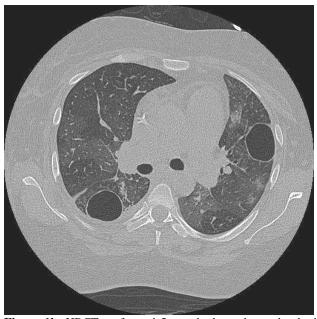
HRCT performed 5 months later shows that both cavities have increased in size, with thinning of the cavity wall and resolution of the intracavitary fluid.
